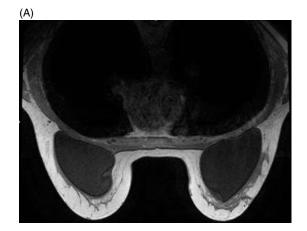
A 60-year-old woman with a known invasive lobular carcinoma in the left breast. (A) Axial T1-weighted MRI demonstrates a low signal region lateral to the left breast prepectoral saline implant, representing the known carcinoma. (B) Axial T1-weighted postcontrast MRI shows an enhancing region (white box) lateral to the implant, representing the malignant process. Abbreviations: MRI, magnetic resonance imaging.
